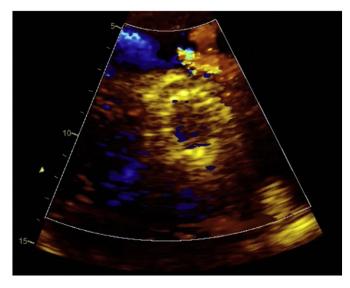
'Transesophageal echocardiogram after valve deployment'. Sagital view of deployed 29-mm CoreValve Evolut-R showed complete expansion of the stent frame and mild paravalvular leak at 12 o'clock
